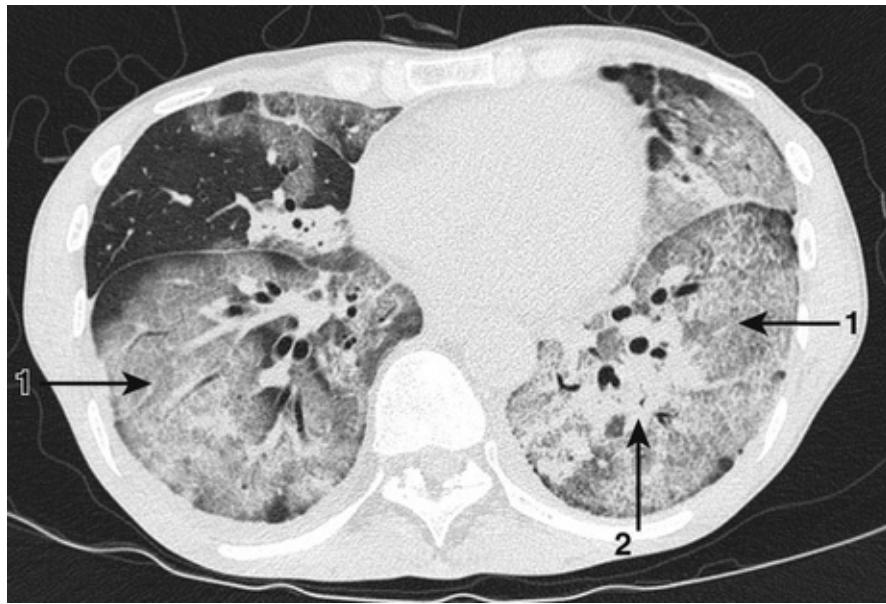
CT lung window settings. Male patient presented with a three-day history of increasing shortness of breath and was severely hypoxic on admission. The CT scan is very suggestive of PCP and shows bilateral ground glass shadowing (1). There are also some areas of consolidation (2). Although no obvious risk factors, blood tests taken on admission showed him to be HIV positive and PCP was confirmed on bronchoalveolar lavage.
